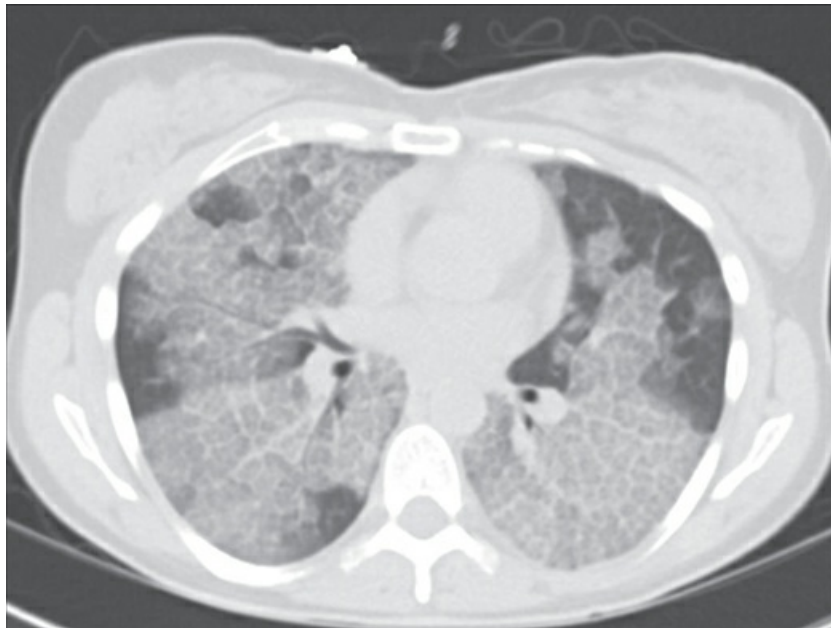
Chest CT scan in a patient with pulmonary alveolar proteinosis showing the characteristic “crazy paving” pattern representing thickened interlobular septa superimposed upon ground-glass opacification.
